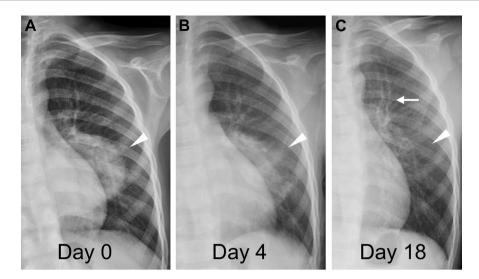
Serial follow-up of chest X-rays (A) at presentation and (B) on the 4th and (C) 18th days after the first visit. Note the gradual resolution of round pneumonia (arrowheads) after antibiotic treatment, although the last film still showed residual interstitial infiltrations and peribronchial thickening of the left upper bronchus, suggesting residual inflammation (arrow).
